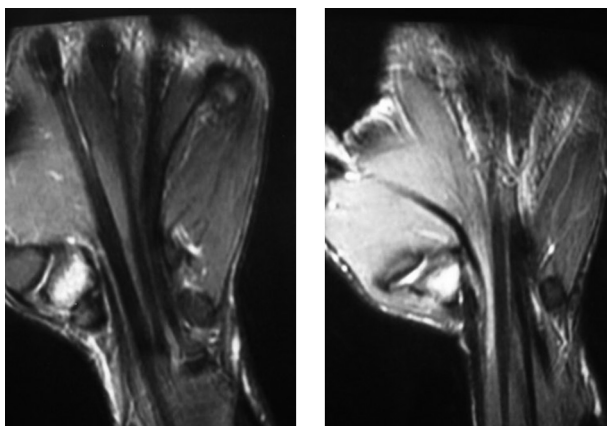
T2-Weighted Magnetic Resonance Imaging Showing Bone Edema in Trapezium.
